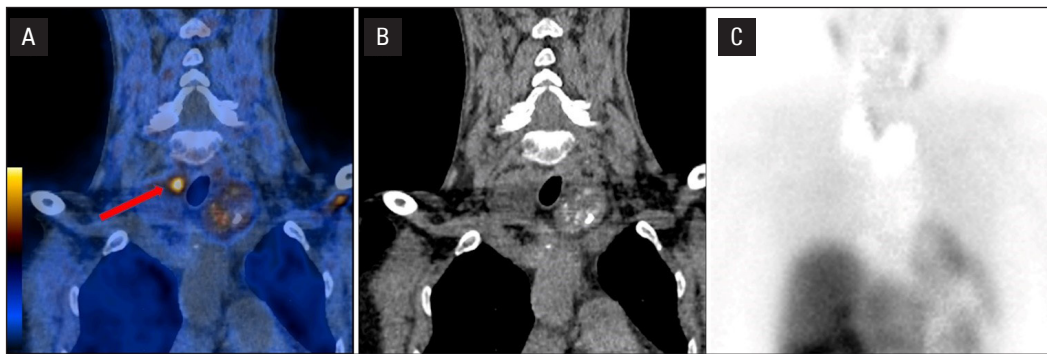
^{18}F -choline positron emission tomography/computed tomography (PET/CT) (A), CT (B) and subtraction scintigraphy (C) coronal scans of a 53-year-old woman with primary hyperparathyroidism and nodular goitre. The images show a choline-avid focus (parathyroid adenoma) by the upper right lobe of the thyroid (A). Subtraction scintigraphy (C) and neck ultrasound were negative. The adenoma was excised and, after the surgery, calcium and parathormone levels normalised
